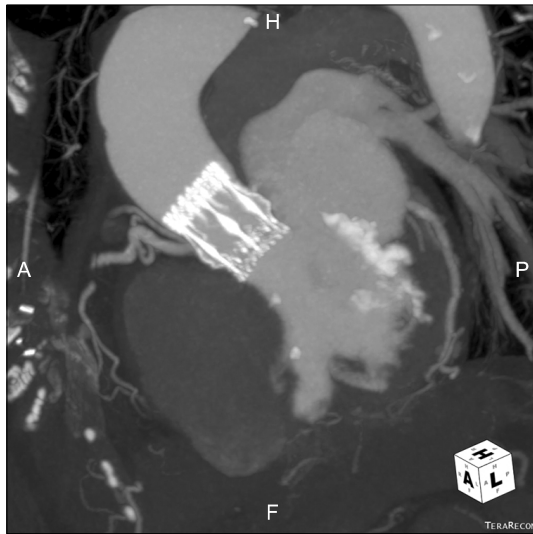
Computed tomography scan performed 1 month post-operatively, showing a well-functioning Perceval S sutureless bioprosthesis. A, anterior; P, posterior; H, head; F, foot.
